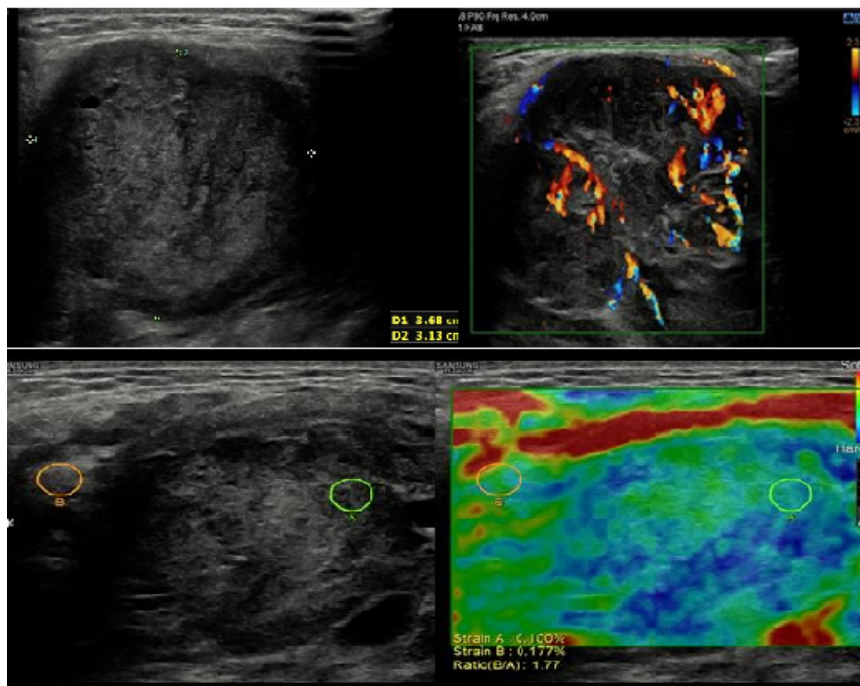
On grey scale USG, the lymph node is round in shape with few areas of internal necrosis showing a mixed pattern of vascularity on the Colour Doppler study. On elastography, the lymph node shows pattern 3 with an SR of 1.7.
